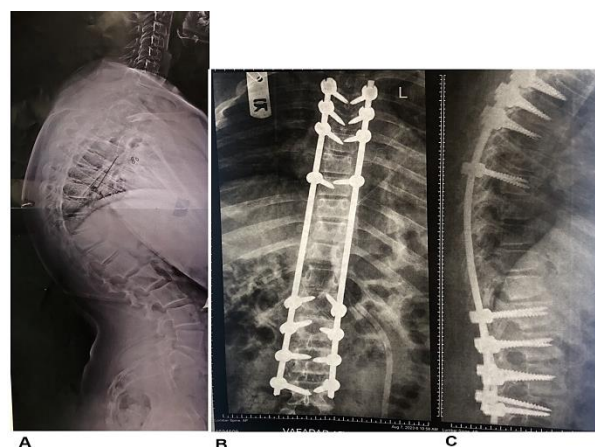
Preoperative anteroposterior (AP) (A) and corresponding postoperative standing radiographs (B, C) of a 15-year-old boy with Scheuermann's kyphosis treated with V-shaped osteotomy. The preoperative kyphotic angle measured 80°, with complete radiographic correction achieved postoperatively.
